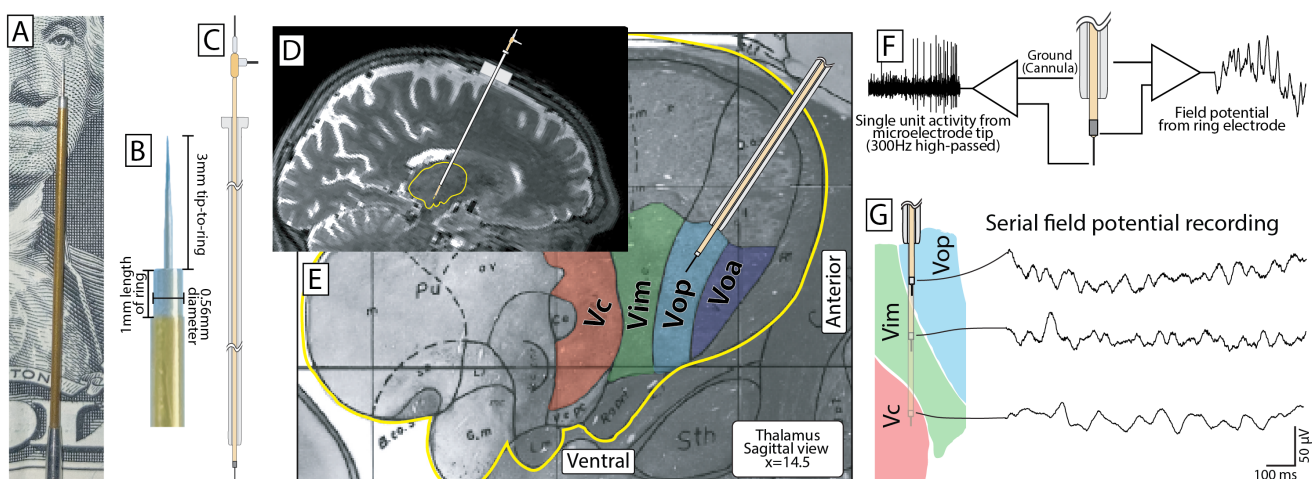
Experimental setup. (A) Recordings were obtained using a clinical DBS electrode both (B) with a high-impedance tip and with a low-impedance ring having surface area of 0.56 mm². The electrode was passed through a cannula (C) that had been inserted into the dorsal thalamus, as shown on a sagittal MRI slice (D), aligned along a trajectory targeting the VIM thalamic nucleus (E). (F) Local field potentials were recorded from the ring electrode and single unit activity was recorded from the microelectrode tip; the shaft of the cannula was referenced in all cases. (G) This study analyzes the field potentials at multiple evenly spaced sites along the trajectory recorded serially as the electrode was passed to target.
